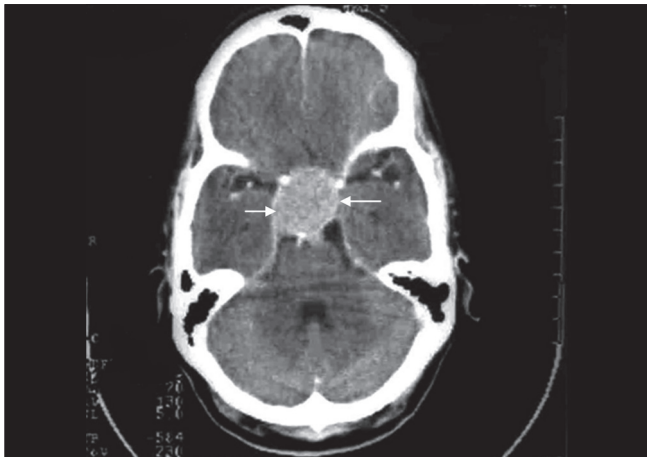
Case 2 – Axial computed tomography scan shows a suprasellar mass (outlined by arrows) suggestive of pituitary adenoma
